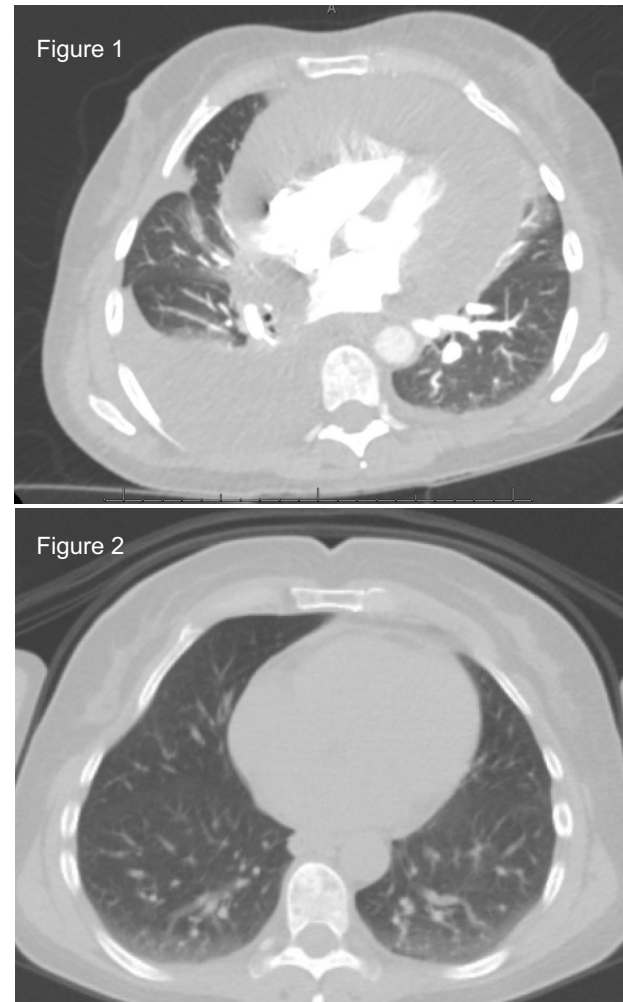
Massive pericardial effusion on CT Chest
